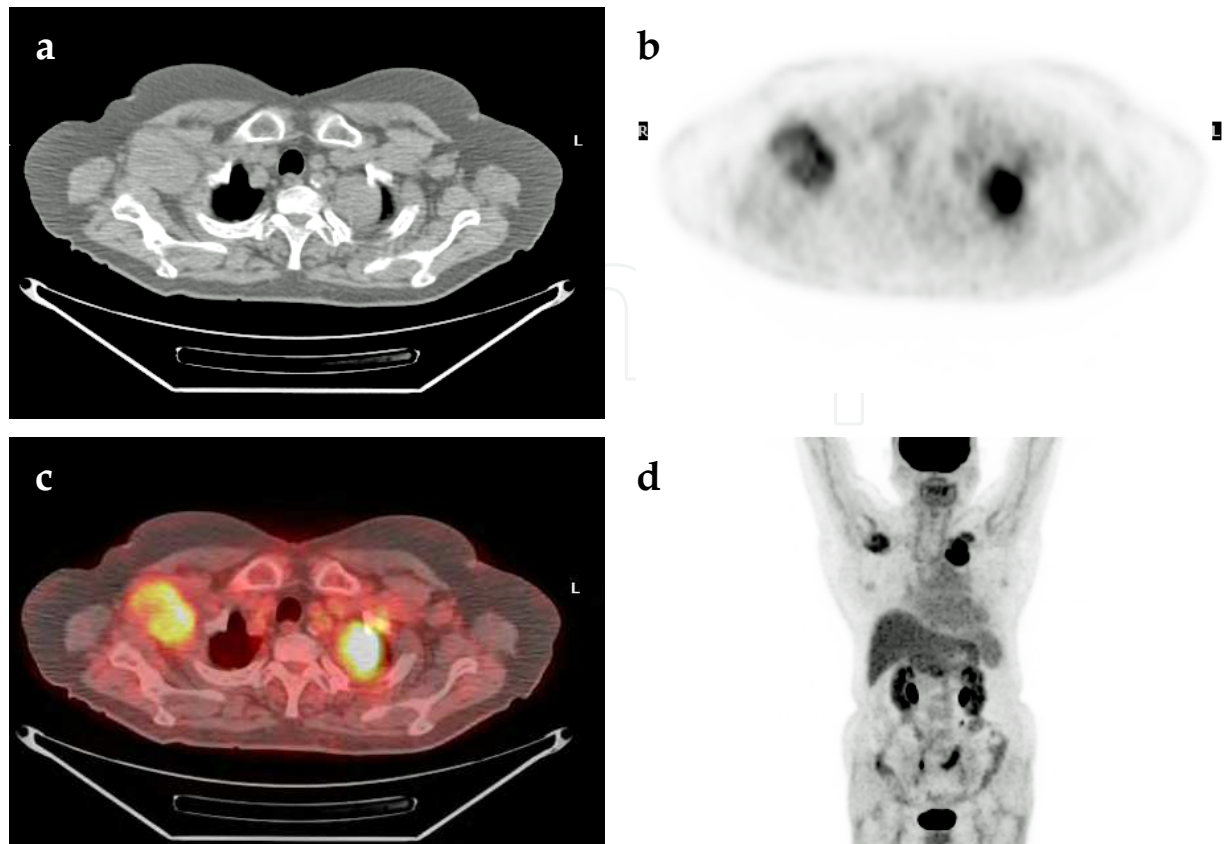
Malignant peripheral nerve sheath tumor (MPNST) located in the right brachial plexus and the left upper lung demonstrated by axial CT (a), axial PET (b), axial PET/CT fusion (c) and coronal PET (d).
